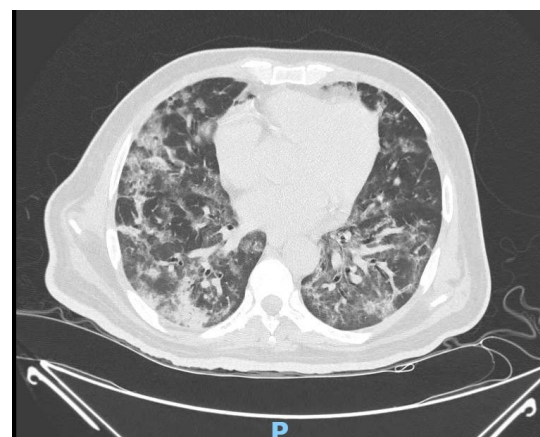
CT chest showing extensive areas of peripherally distributed foci of consolidation and ground glass opacities in both lungs.
